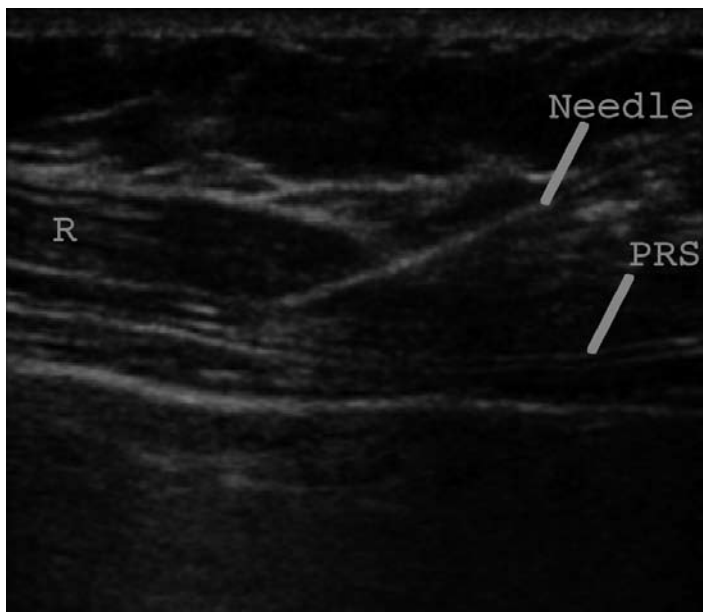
The first ultrasound image shows a needle with the needle tip positioned below the rectus muscle. The second ultrasound image is 1 second later as local anaesthetic is injected to lift the rectus muscle off the posterior rectus sheath. R= rectus muscle, I= injectate (local anaesthetic), PRS= posterior rectus sheath (twin 'tram'-lines).
